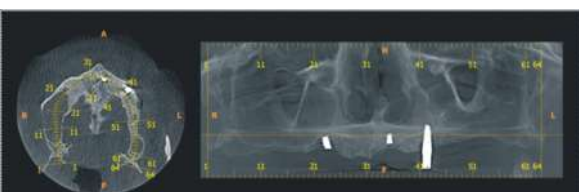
CBCT to evaluate the status of remaining implants & bone.
